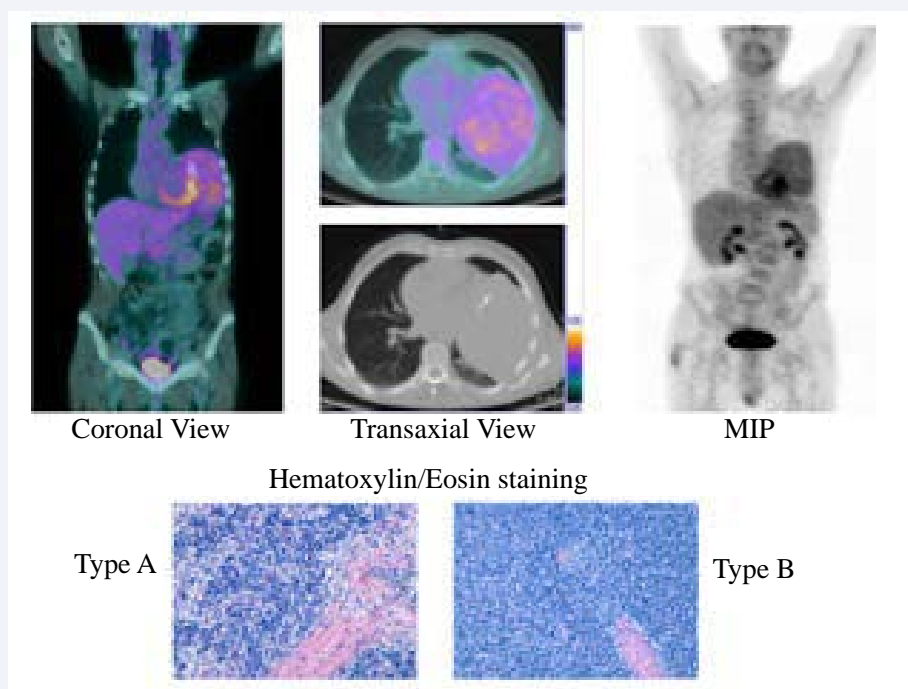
Figure shows, in its superior part, coronal and transaxial view as well as MIP of the PET/CT exam: it is visible the left pulmonary mass without evidence of increased metabolism in mediastinum or remote areas and an only moderately increased tracer uptake (SUV max 3.5). It is clear as the tracer distribution is largely heterogeneous with hot spots immersed in a relatively of background, without any evidence of necrosis.
